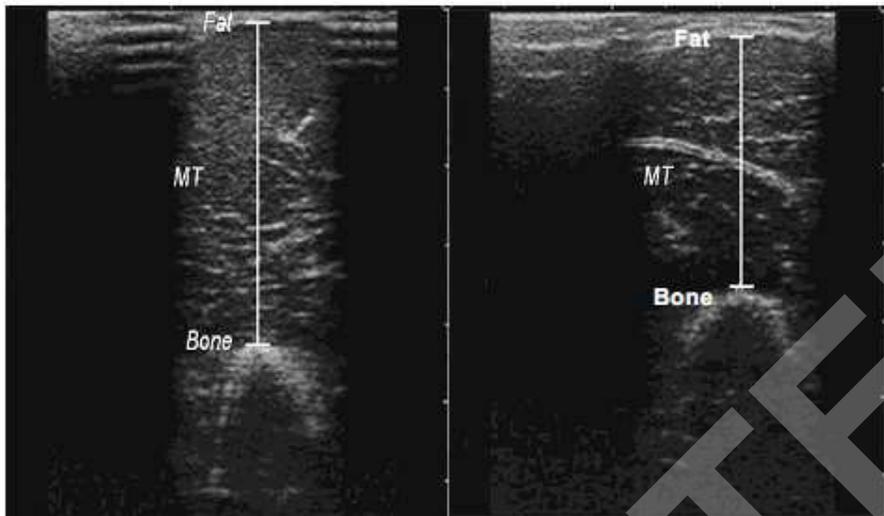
Ultrasonographic images representing muscle thickness of the elbow flexors (left) and of the elbow extensors (right).
